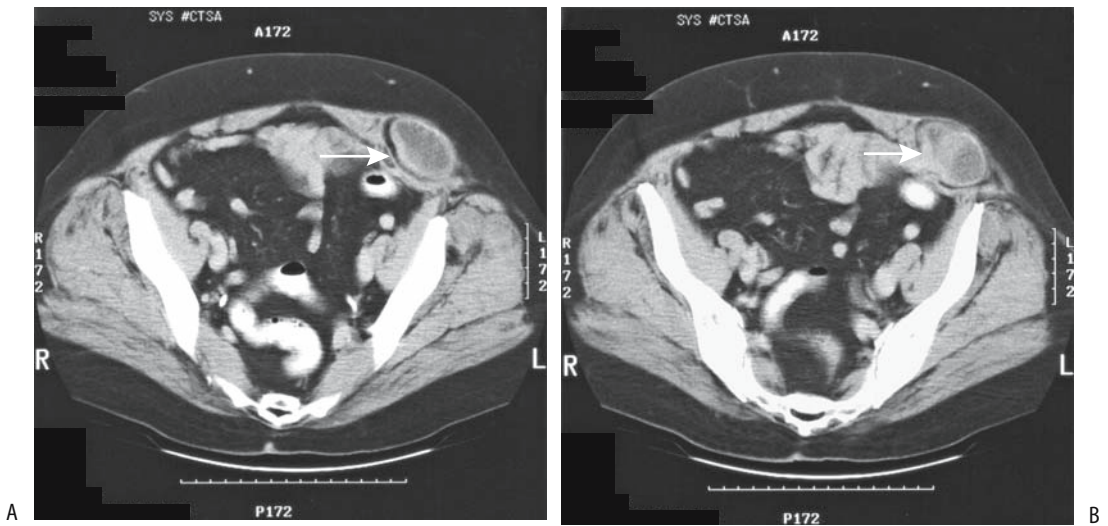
A,B: Two CT images of a spigelian hernia (arrows).
